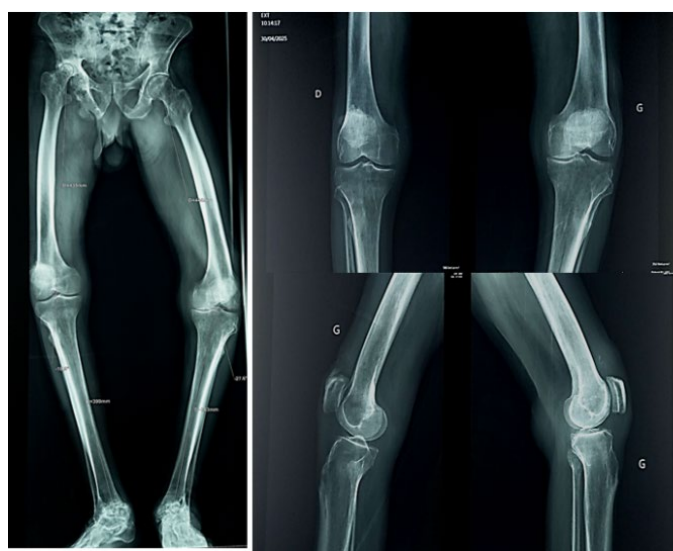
Knee radiographs and long-leg alignment radiograph (pangonogram) demonstrating bilateral genu varum associated with left medial femorotibial and femoropatellar osteoarthritis.
